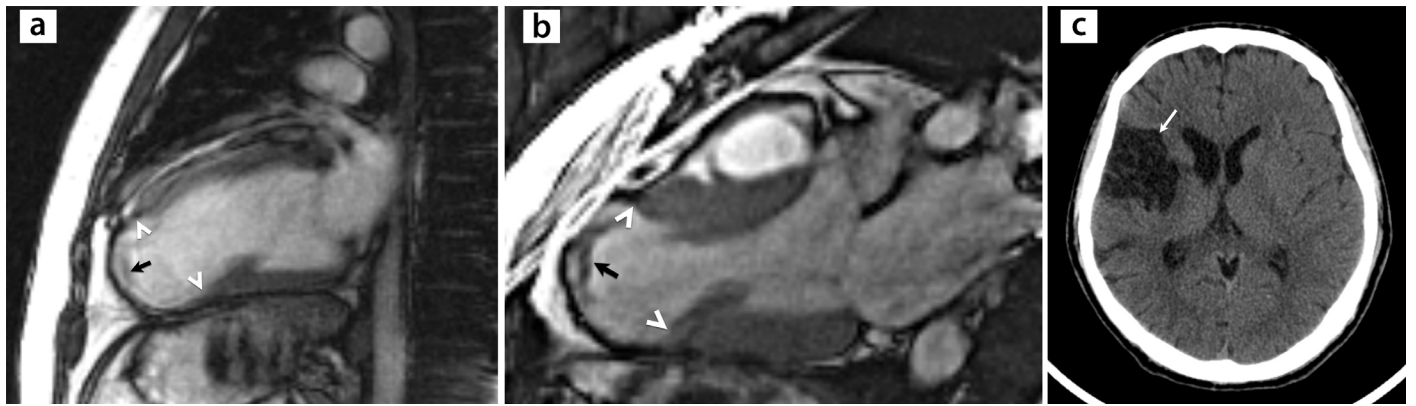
(a-c) A 73-year-old male patient with a history of myocardial infarction and cerebrovascular events underwent cardiac magnetic resonance (MR) imaging with a suspected left ventricular thrombus. Cardiac MR images of a left ventricle apical true aneurysm. Balanced steady-state free precession MR images with (a) a two-chamber view during mid-diastole and (b) a left ventricular outflow tract view during end systole revealing left ventricular apical dilatation with smooth transition between the healthy and thinned myocardium (arrowheads). Note the left ventricular thrombus (arrows). (c) Axial cranial computed tomography image depicting chronic right middle cerebral artery territory infarction (arrow). See also Supplementary Video 1.
